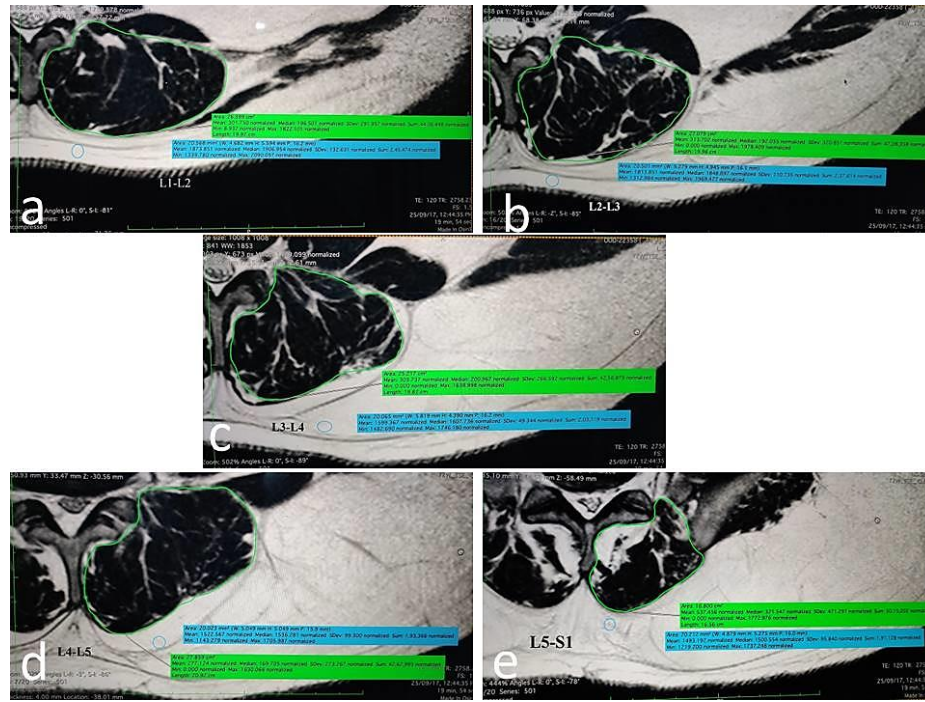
Measurements of muscle disc ratio (MM+ES) on axial T2-weighted images at L1-2 (a), L2-L3 (b), L3-4 (c), L4-5 (d), and L5-S1 (e) lumbar disc levels in the same patient
